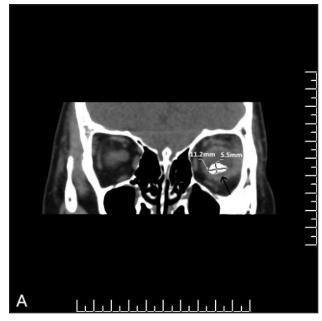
Computed tomography scan showed a glass intraocular foreign body with a maximum diameter of 11.2 mm and minimum diameter of 5.5 mm located in the vitreous cavity (arrow).
